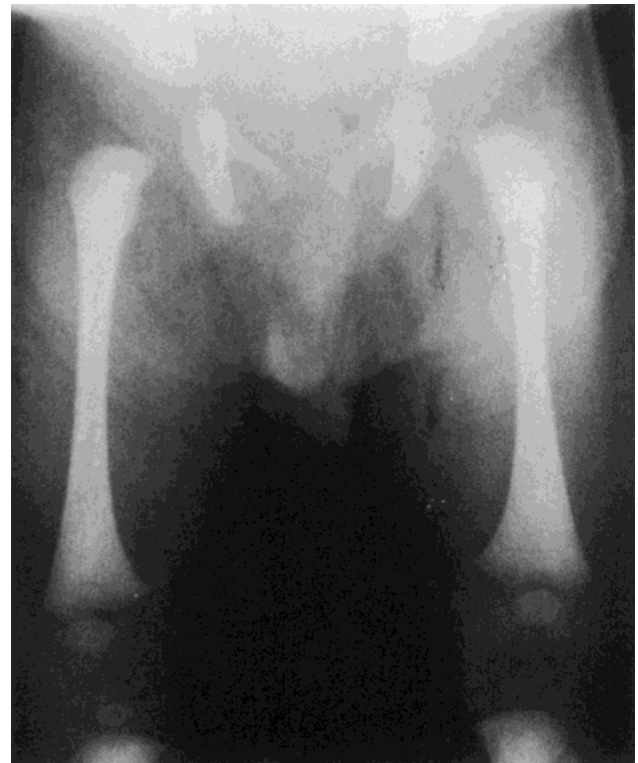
Case 1. X-ray of long bones of the lower limbs showing cortical thickening of long bones.
